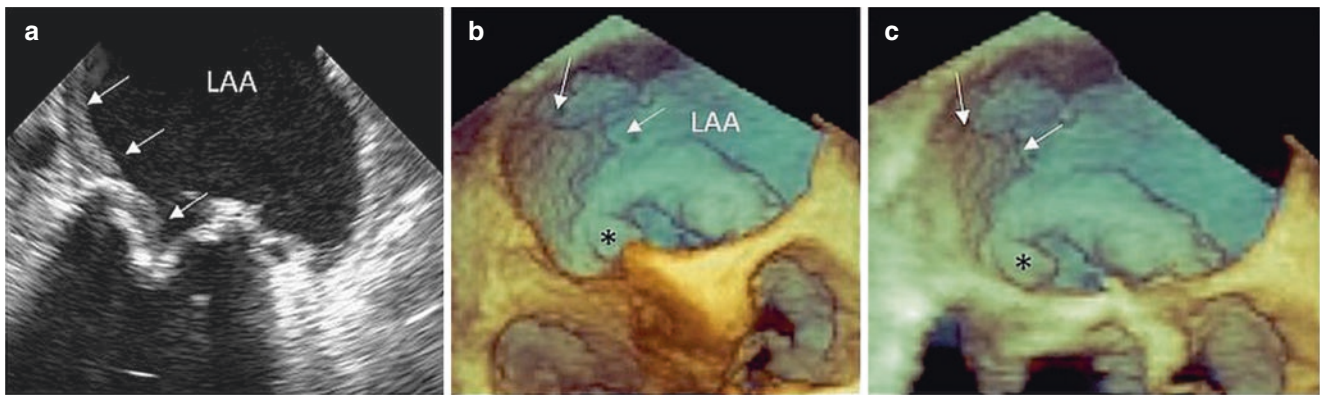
Huge thrombus (arrows) in left atrial appendage visualized by two-dimensional transesophageal echocardiography (a) and transesophageal 3DE image. Volume rendering transversal cut plane from
